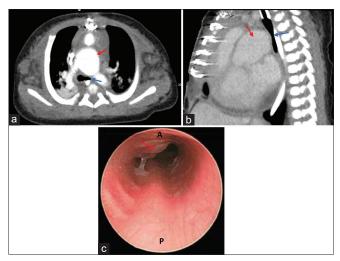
(a) Axial and (b) Sagittal computed tomography imaging showing the dilated main pulmonary artery (red arrow) compressing the left mainstem bronchus (blue arrow) near the carina, (c) Bronchoscopy showing external pulsatile compression from the pulmonary artery (arrowhead) of the distal trachea and left mainstem bronchus
